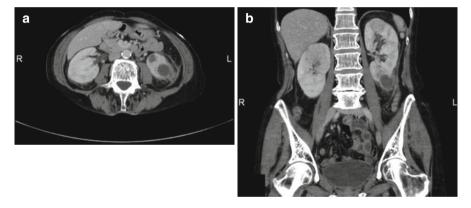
Contrast enhanced CT scan of a 56-year-old female patient showing an abscess-forming pyelonephritis on the left-hand side. (a) Transverse plane; (b) Coronal plane
